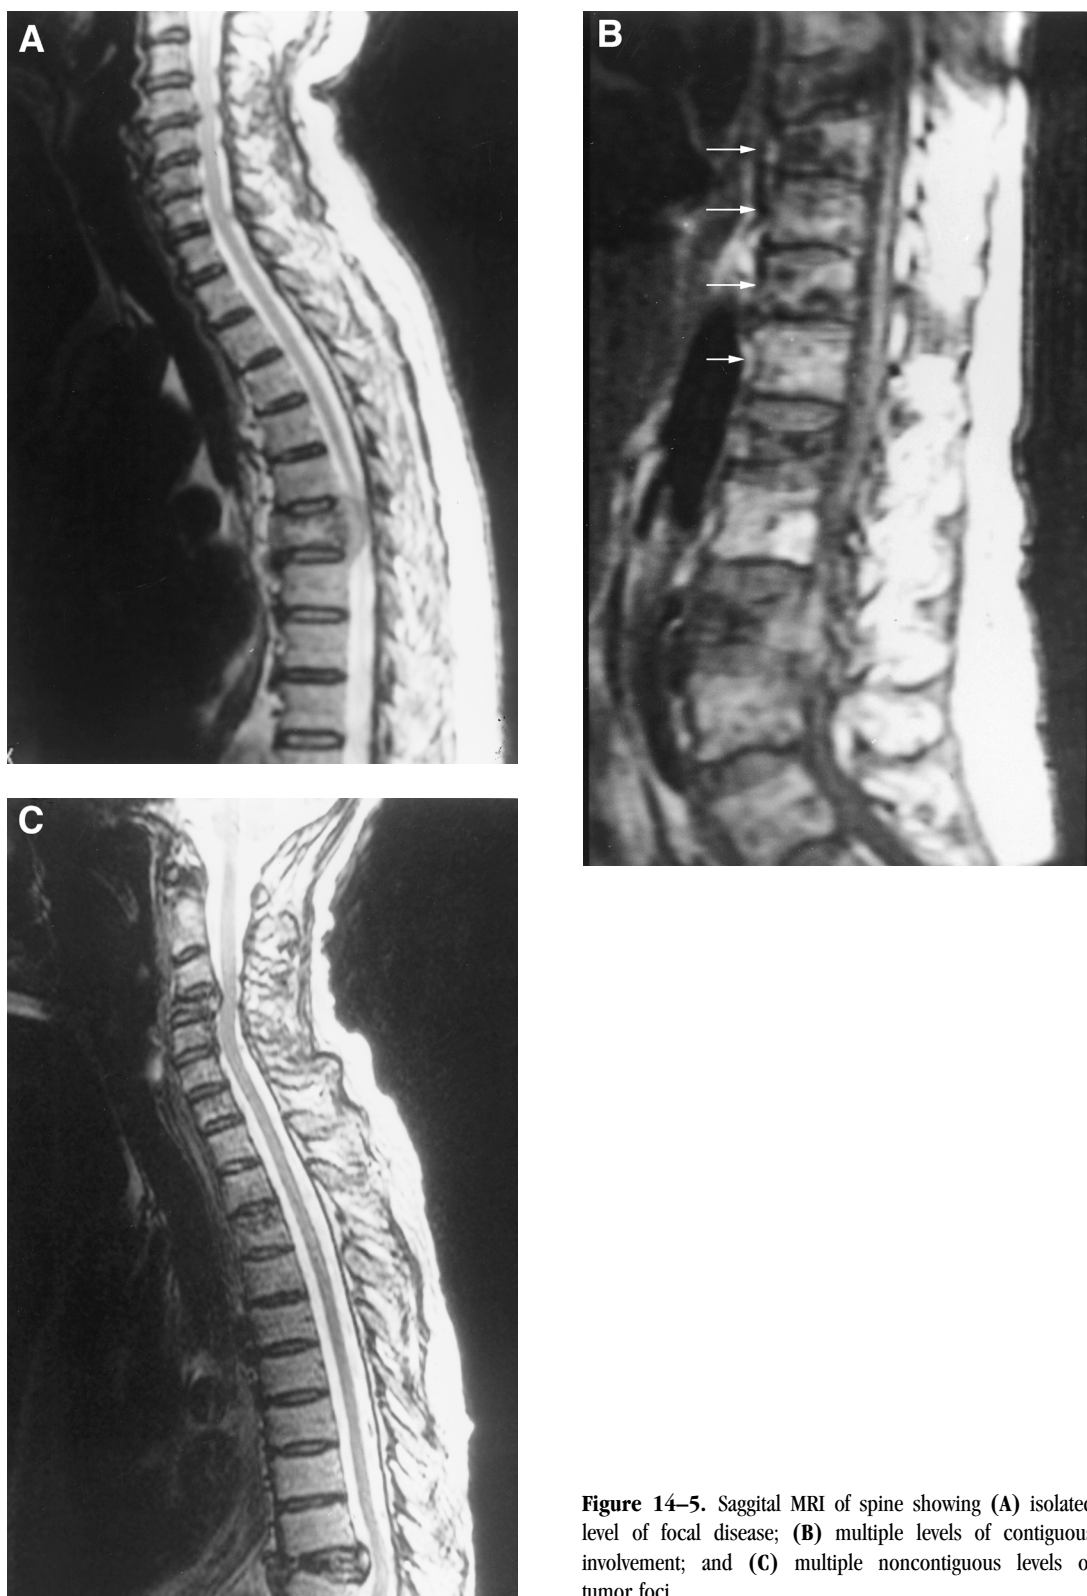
Sagittal MRI of spine showing (A) isolated level of focal disease; (B) multiple levels of contiguous involvement; and (C) multiple noncontiguous levels of tumor foci.
